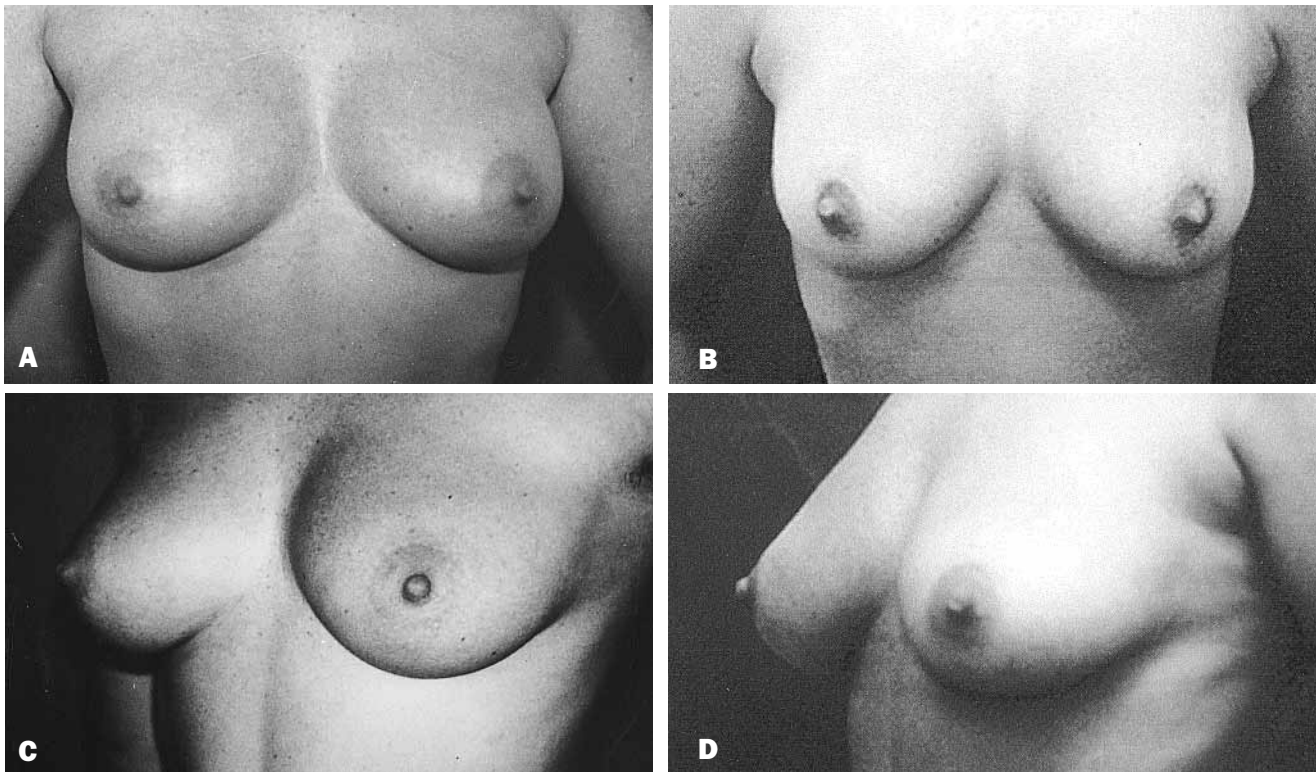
A, C, Preoperative photographs of a 29-year-old woman with moderate breast hypertrophy. B, D, Postoperative views 6 months after ultrasound-assisted lipoplasty through a submammary fold incision and emulsification of 500 mL of fat per site.
